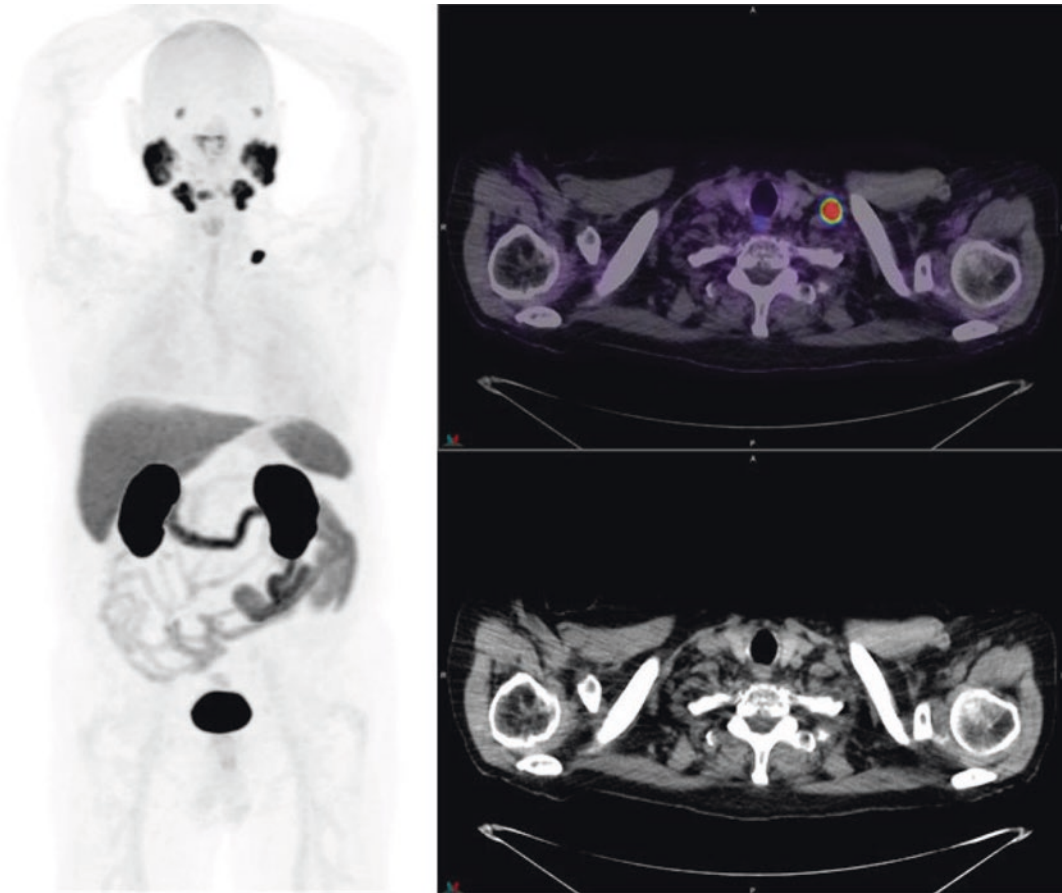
A male patient with a history of prostate cancer presenting with biochemical recurrence with PSA of 1.49 ng/ml. 68Ga-PSMA PET/CT images demonstrate a
